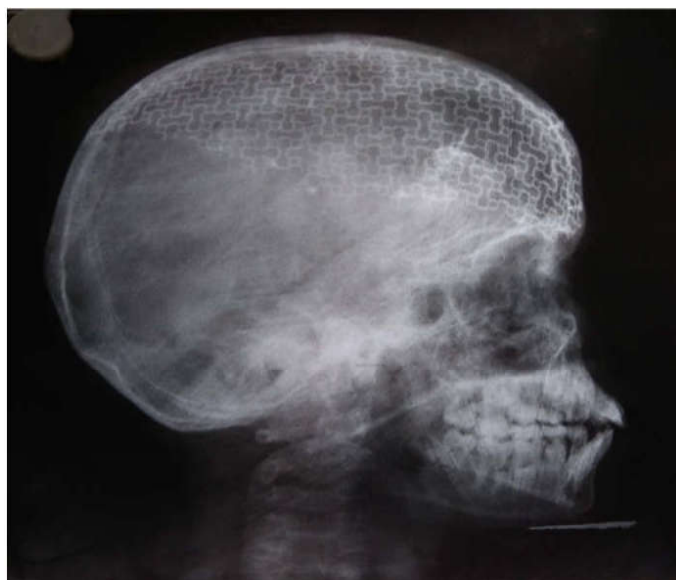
Postoperative X-Ray Showing Titanium Mesh in Situ.
